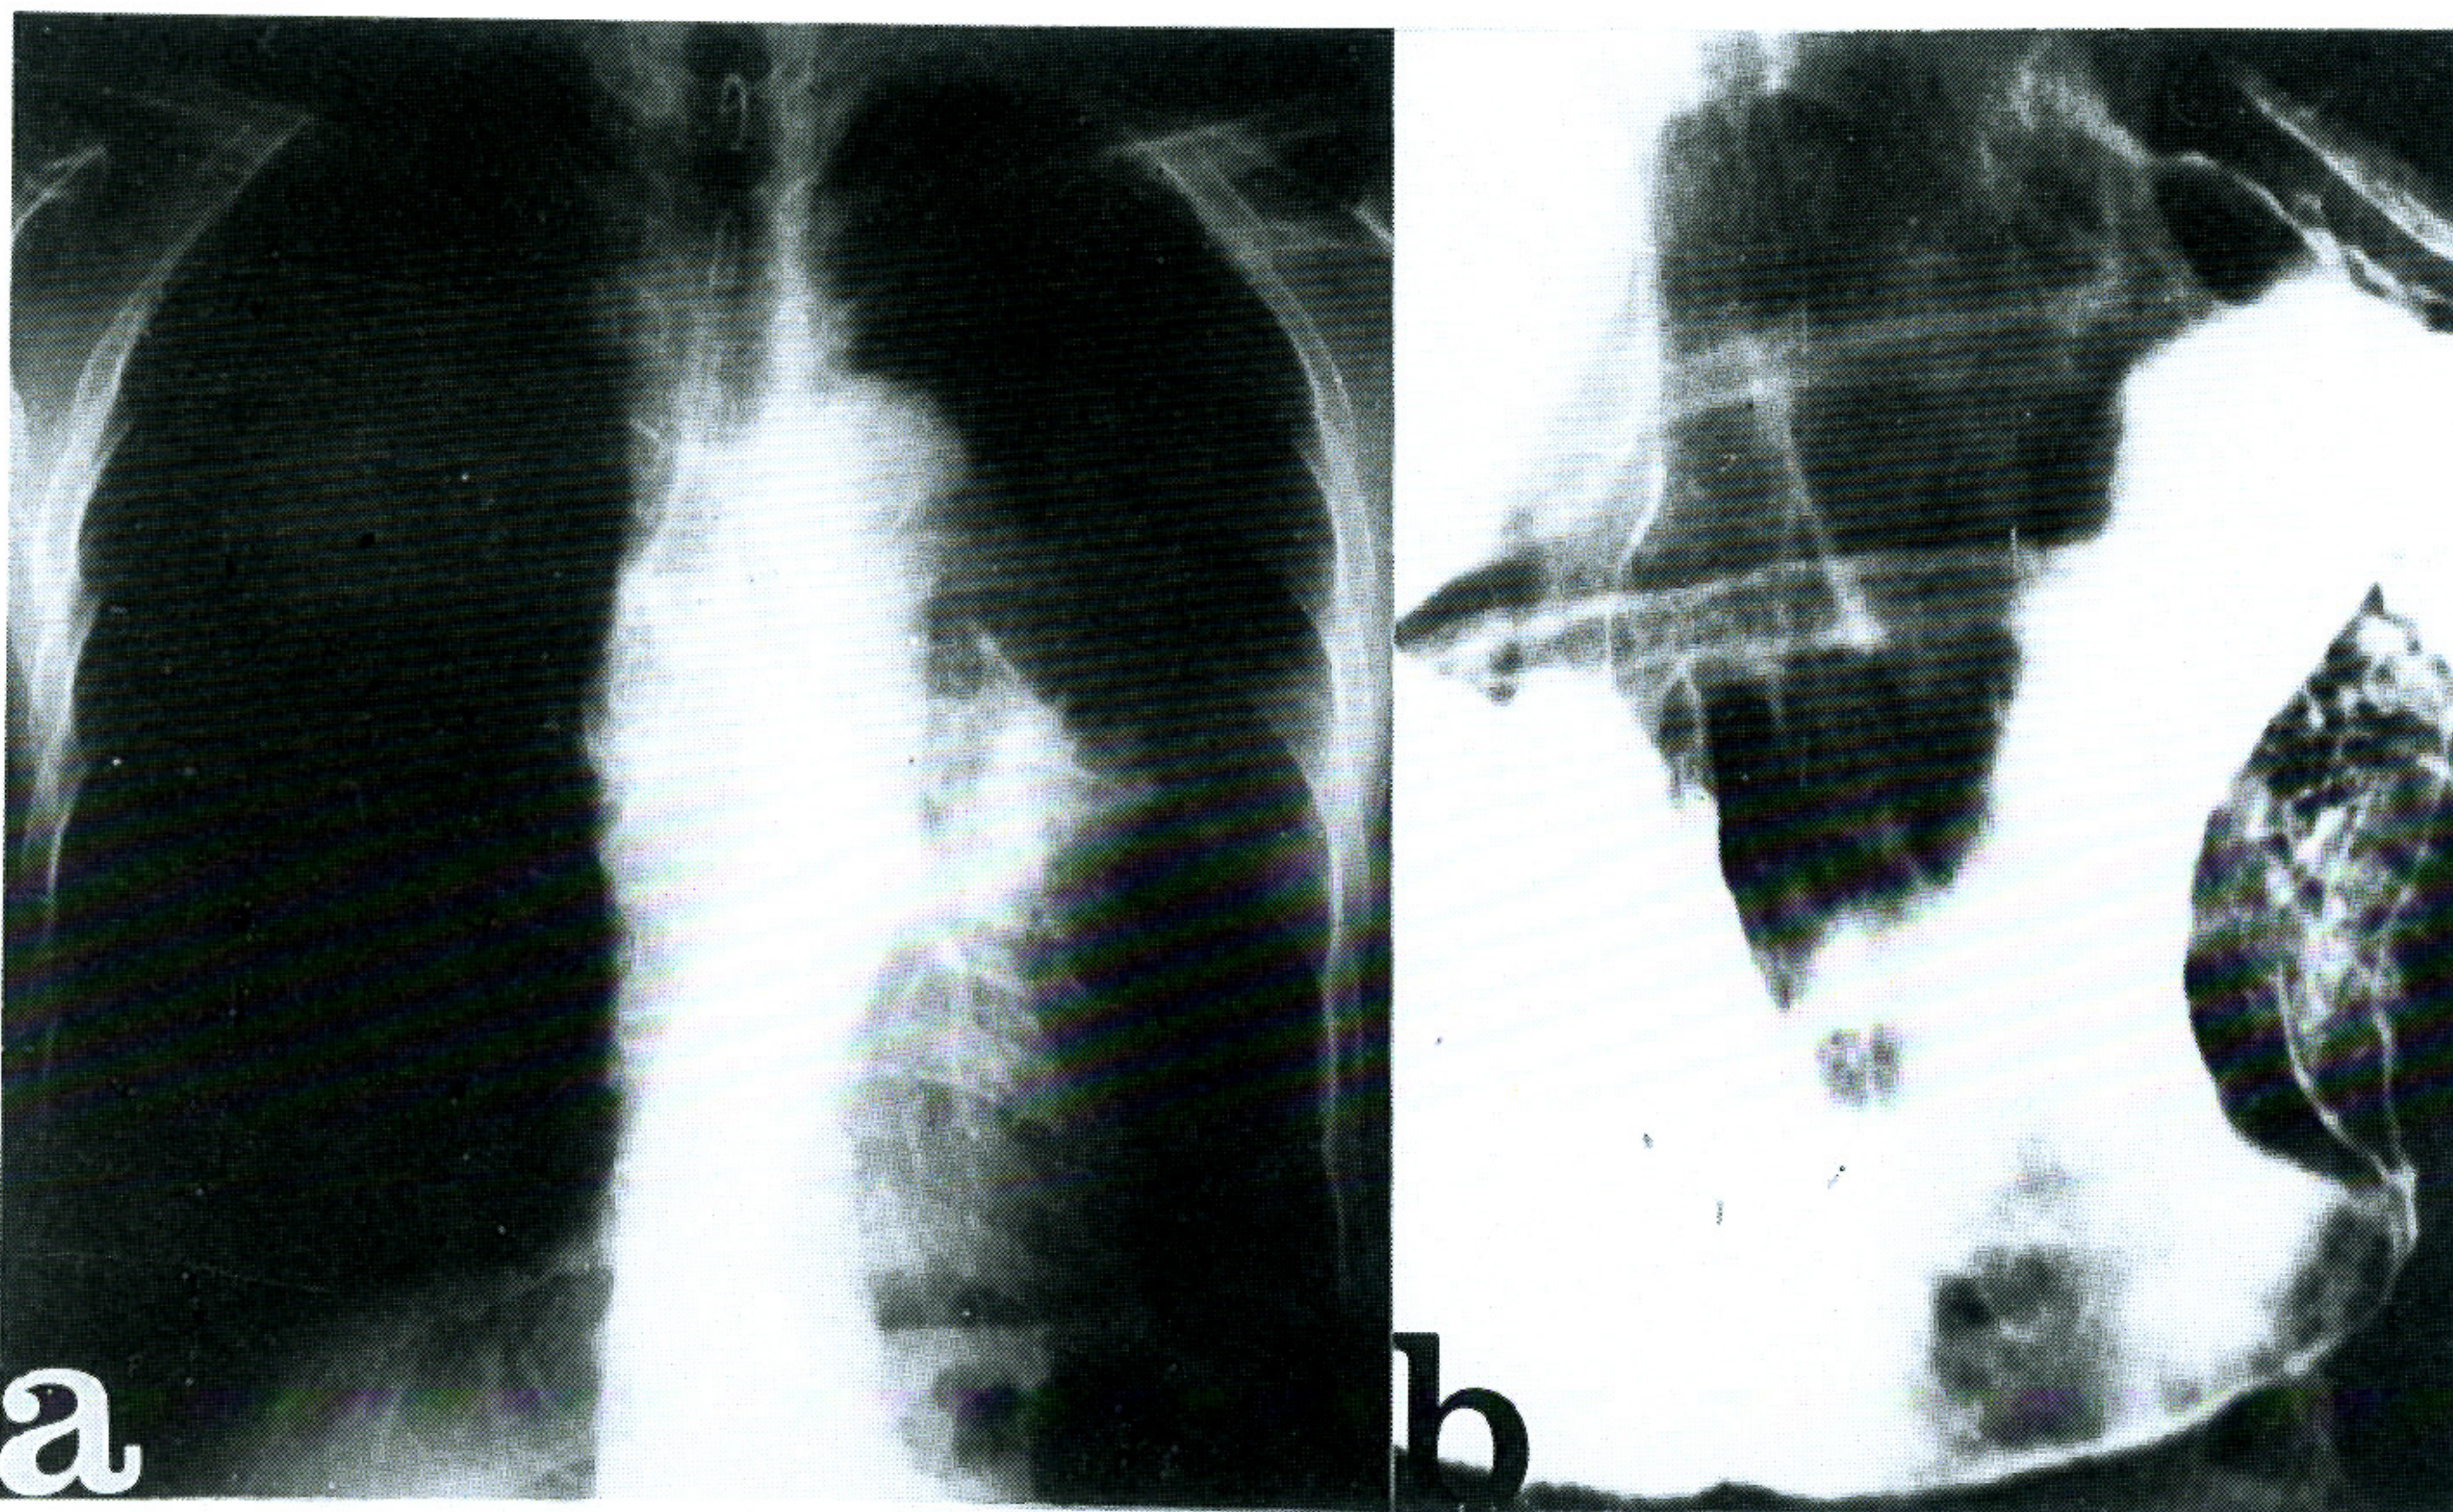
An X-ray film of the chest shows a ill-defined mass in the left upper lung field (4a). The upper gastrointestinal radiography reveals a large polypoid filling defect on the greater curvature side of the midbody (4b).
